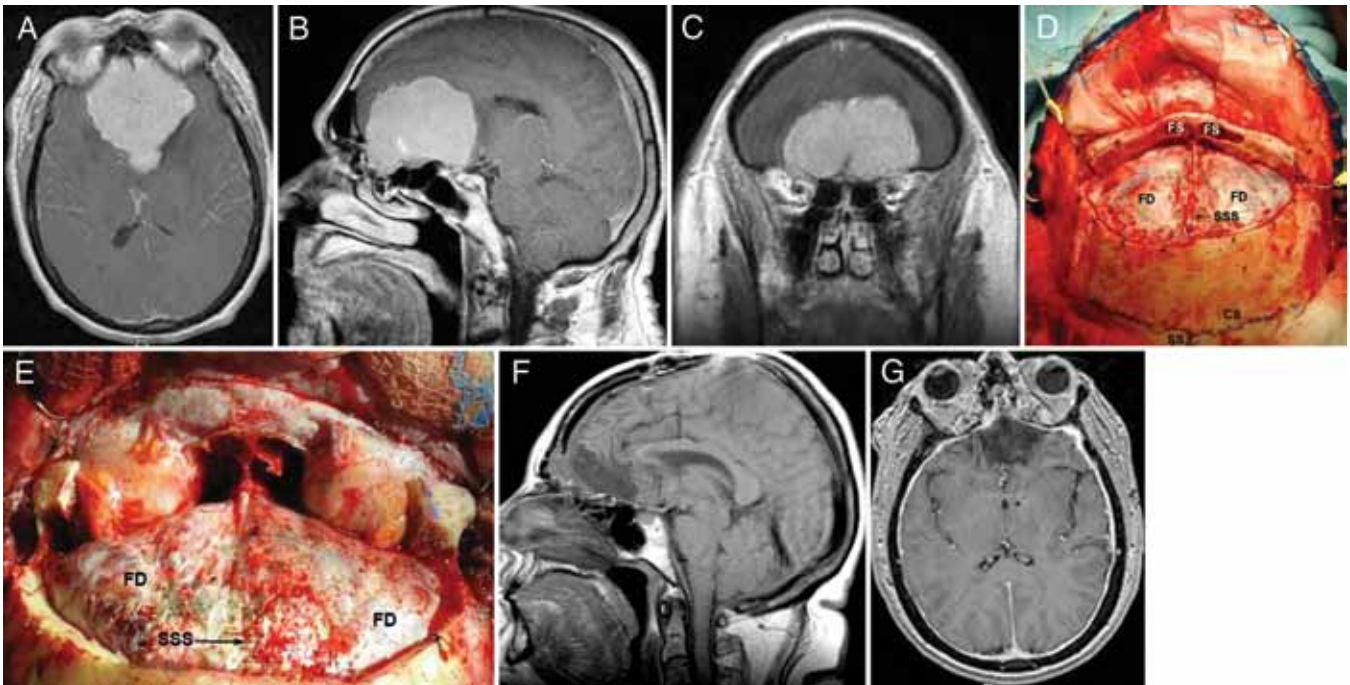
Case 1. Preoperative T1-weighted postcontrast axial (A), sagittal (B), and coronal (C) MR images demonstrating a giant olfactory groove meningioma with extension into the cribriform plate and ethmoidal sinus. Intraoperative photographs showing the epidural exposure after bifrontal craniotomy (D) and supraorbital bar removal (E). Postoperative T1-weighted postcontrast sagittal (F) and axial (G) MR images obtained 2 years later do not show any residual or recurrent meningioma.
